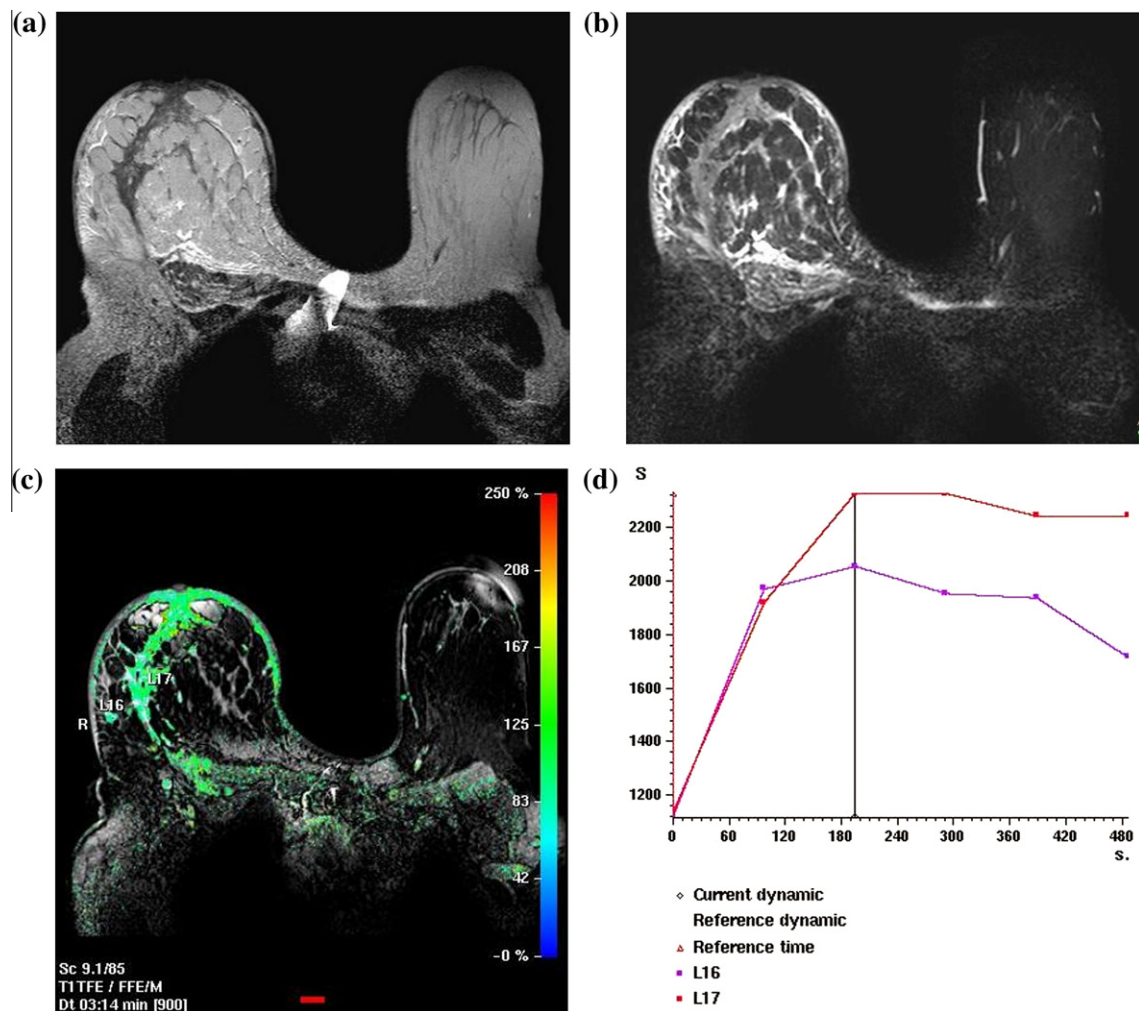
Right inflammatory breast cancer. Axial (a) T2-weighted and (b) T2-STIR images that show asymmetrical enlargement of the right breast, diffuse soft tissue infiltration and distortion of intermediate-low SI, considered edematous changes, skin thickening, nipple retraction, peri- and intramuscular pectoral edema. (c) Axial THRIVE image 3 min post contrast with color overlay shows intense enhancement of the breast infiltration and axillary skin enhancement. Note pectoral enhancement. (d) Time/SI analysis shows early peak of contrast uptake at 190 s. with corresponding SI% of 83–104% and type III (early wash out) curve pattern.
